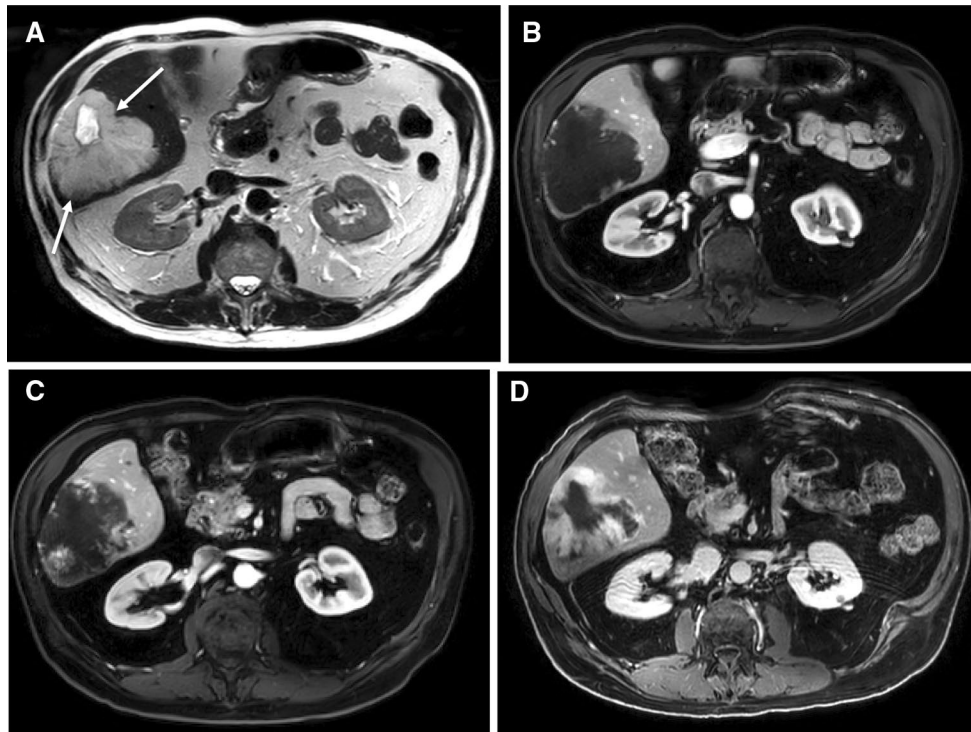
MRI of liver hemangioma. The axial T2-weighted image a shows a giant hemangioma in hepatic segment 6 (arrows) with central cystic change contrasting with the less hyperintense periphery. Fat-suppressed T1-weighted postcontrast arterial phase (b), portal phase
